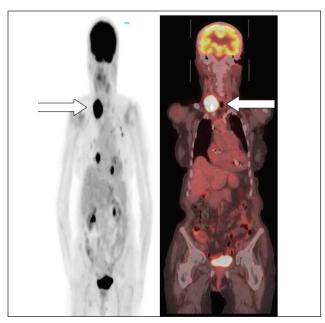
PET-CT scan shows the large intensely glucose avid right thyroid mass (*arrow*) with multiple pulmonary nodules bilaterally that were intensely glucose avid as well.
